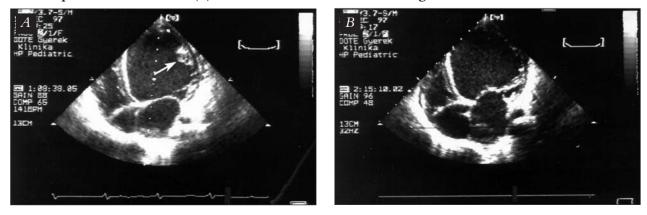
(A) Four chamber view 2D echocardiogram: the left ventricular thrombus (arrow) diminished in size compared to the CT scan. (B) Four chamber view 2D echocardiogram: no thrombus can be detected
